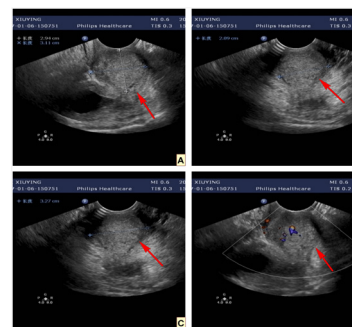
Transvaginal sonography: Transvaginal sonography showed a medium echo with a clear margin in the cervical canal. The echo measured 29 mm × 28 mm × 32mm. The echo measured 29 mm × 28 mm × 32mm.
